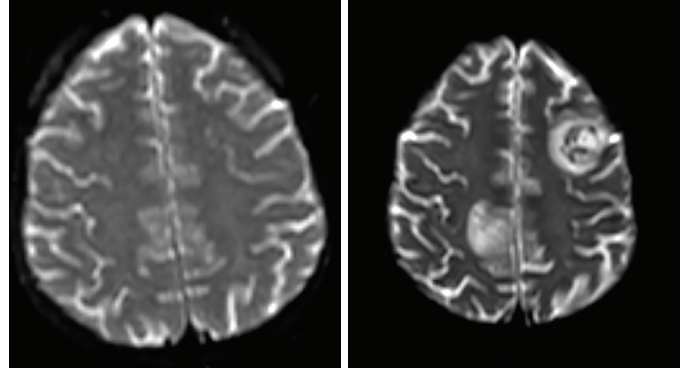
Comparative axial diffusion-weighted magnetic resonance imaging (MRI) images of the brain. Left: Initial MRI showed no abnormal signal intensity or structural lesions. Right: Follow-up MRI 17 days later demonstrated new well-defined ring-enhancing lesions in both cerebral hemispheres, consistent with evolving cerebral fungal abscesses. The interval of the development of these lesions correlated with the patient's neurological decline and supported the diagnosis of disseminated invasive aspergillosis.
